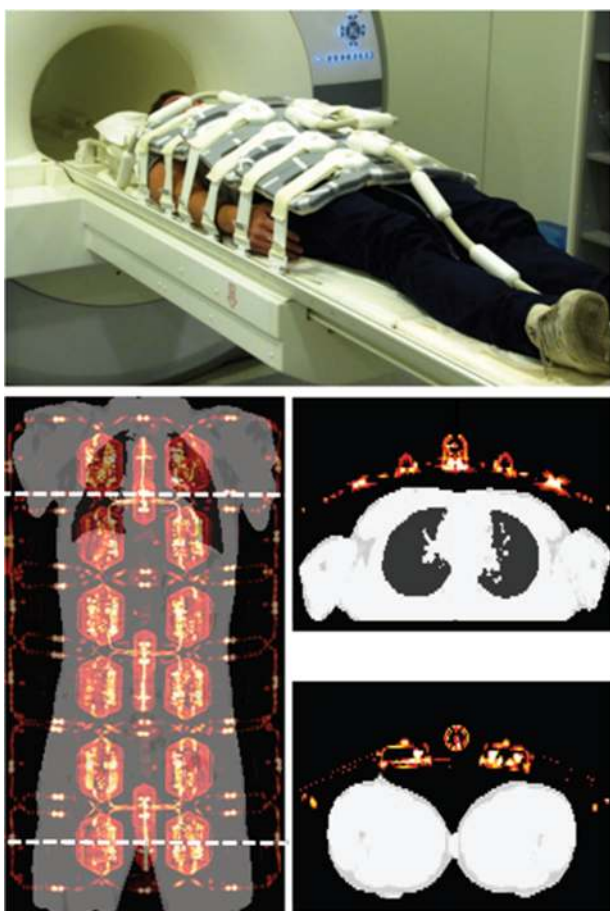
Attenuation correction of flexible RF coils. Top: MR imaging setup of an exemplary volunteer with three overlapping RF surface coils. Bottom: combined four-class attenuation map of the volunteer with the registered CT-based attenuation maps of the overlapping RF coils. The dashed lines show the axial location of transverse slices. Adapted with permission from Kartmann *et al.*, "Integrated PET/MR imaging: Automatic attenuation correction of flexible RF coils," *Med. Phys.* 40(8), 082301 (14pp.) (2013). Copyright 2013 by AAPM.
